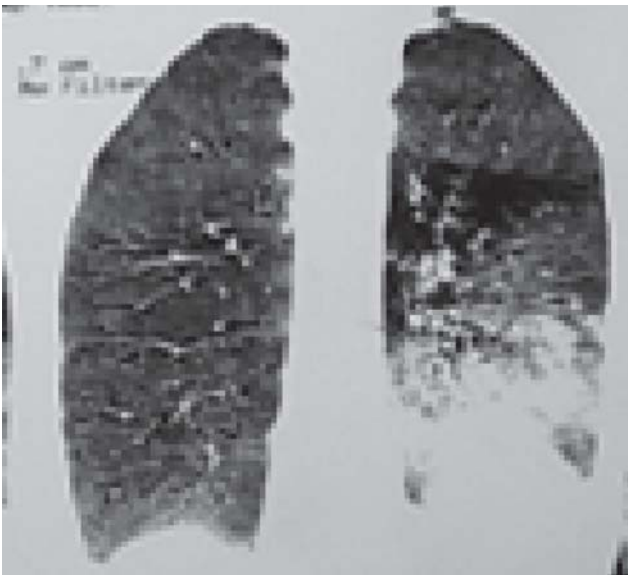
High resolution computed tomography of chest showing left lower lobe consolidation.
